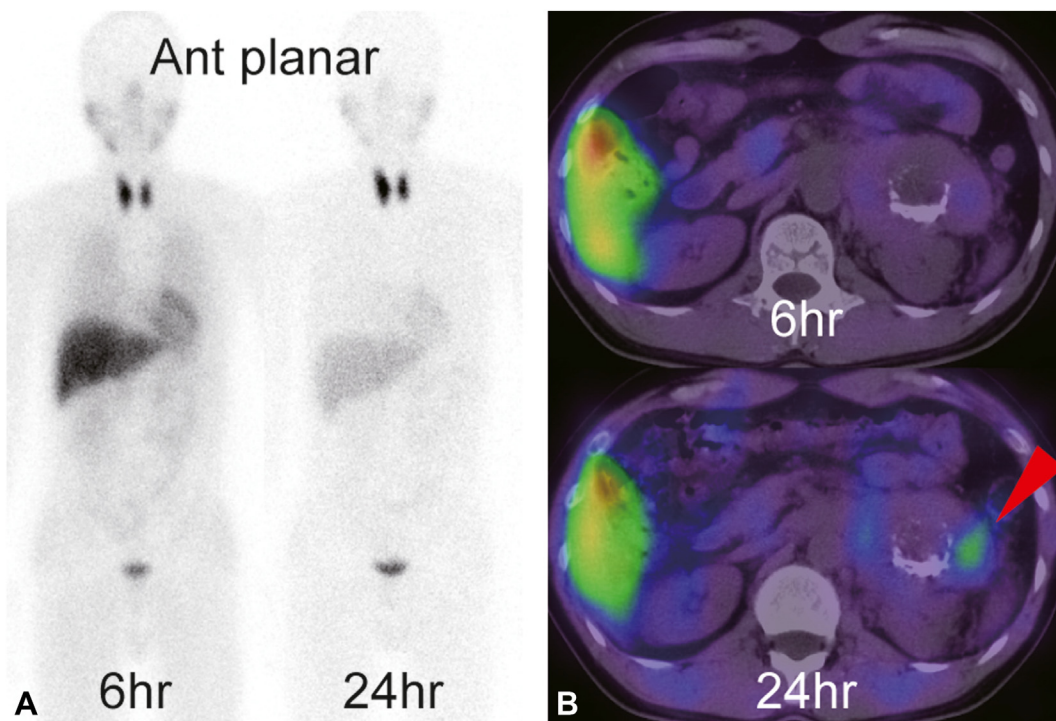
A, ^{123}I -meta-iodobenzylguanidine scintigraphy showing no uptake in the tumor at 6 and 24 hours after injection. B, ^{123}I -meta-iodobenzylguanidine single-photon emission CT/X-ray CT demonstrates no uptake at 6 hours and only insignificant accumulation (*red arrow*), lower than hepatic physiologic uptake at 24 hours after injection. Overall, the results of nuclear medicine studies did not confirm the diagnosis of paraganglioma.
